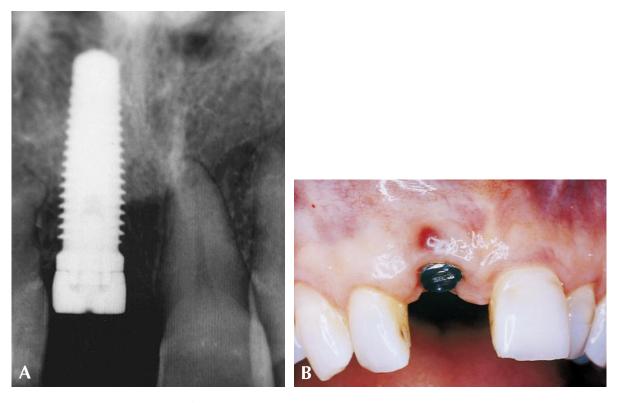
A, Radiograph of incompletely seated provisional component that caused B, adverse tissue reaction.
